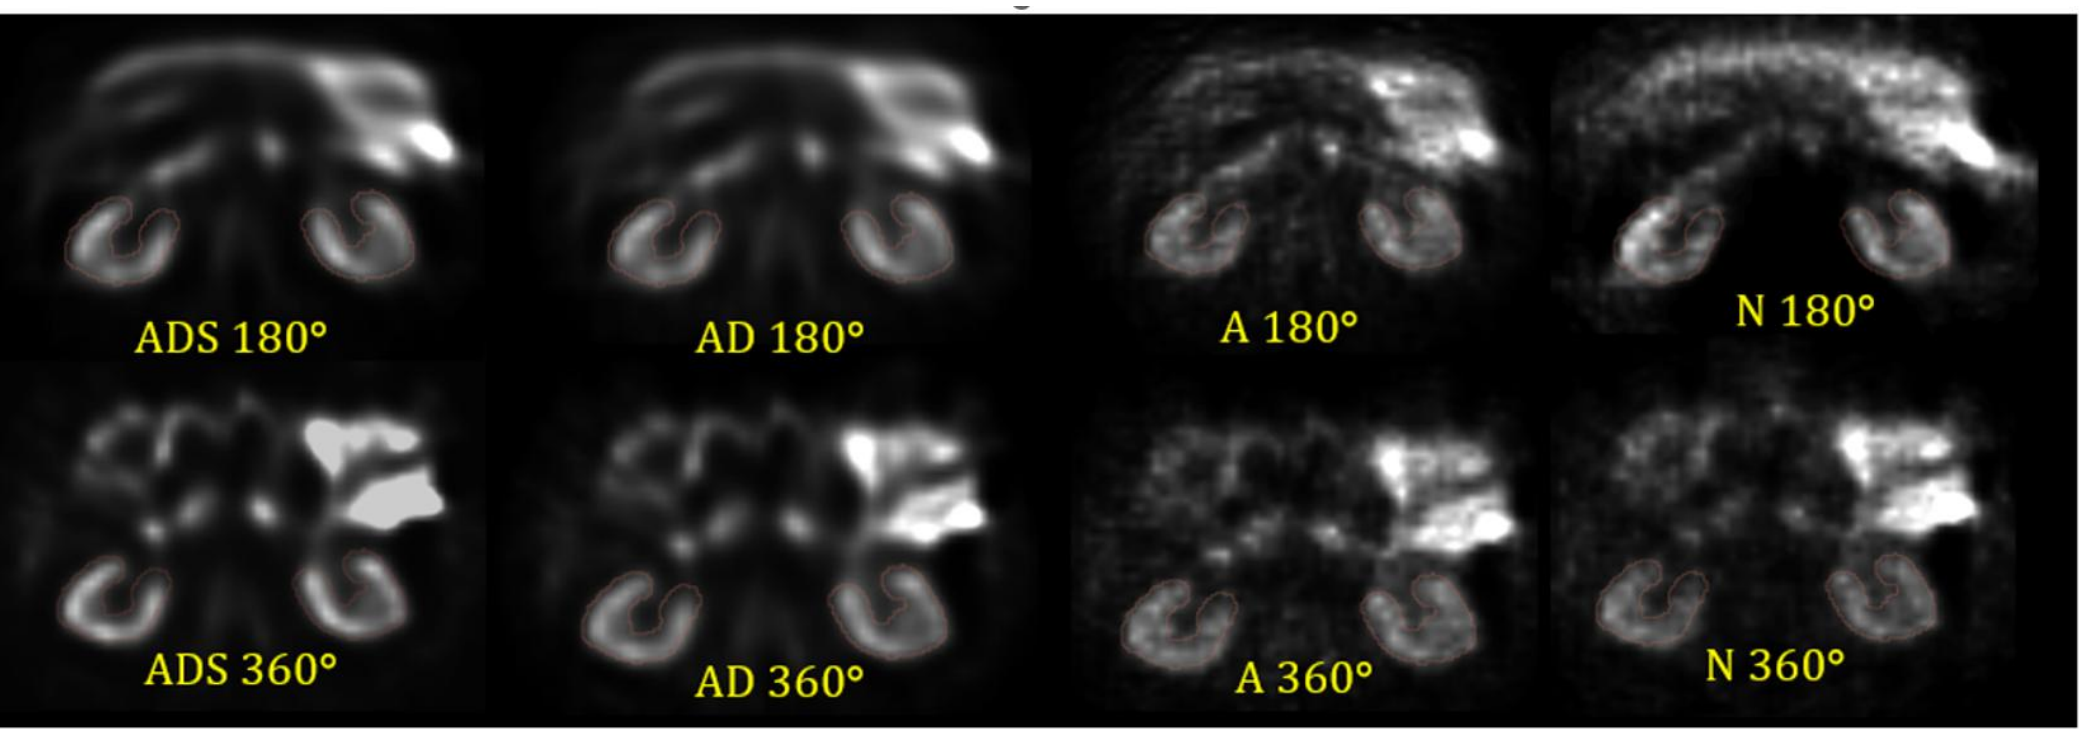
Examples of SPECT images reconstructed with different compensation methods (ADS, AD, A, N) and projection data (180° and 360°).
